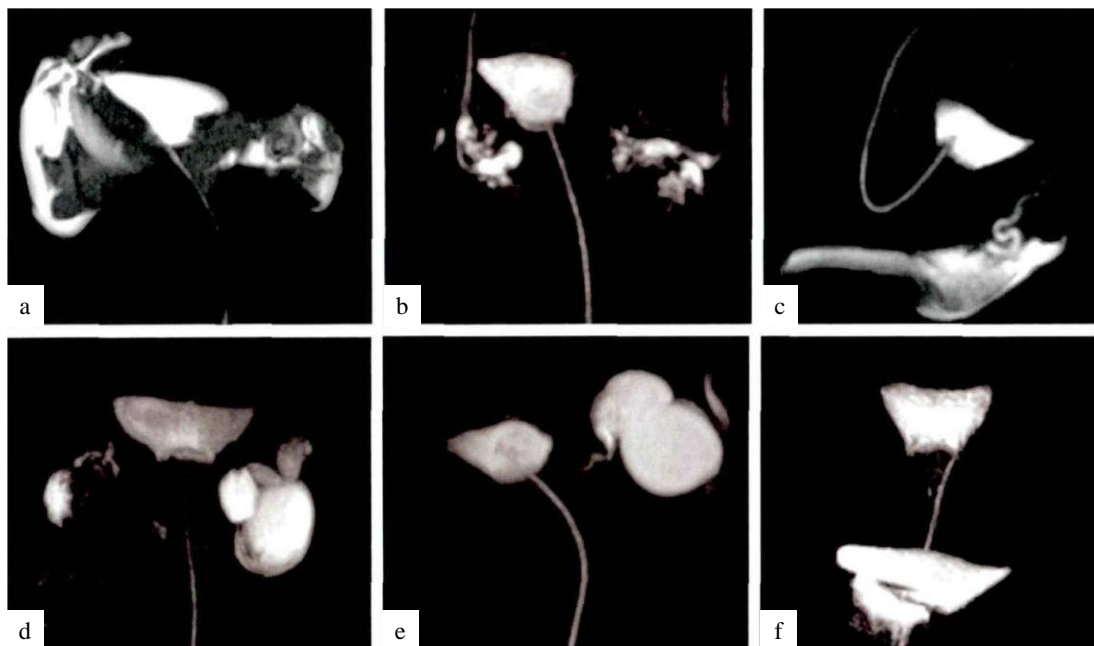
Fallopian tube imaging results under MRI.
